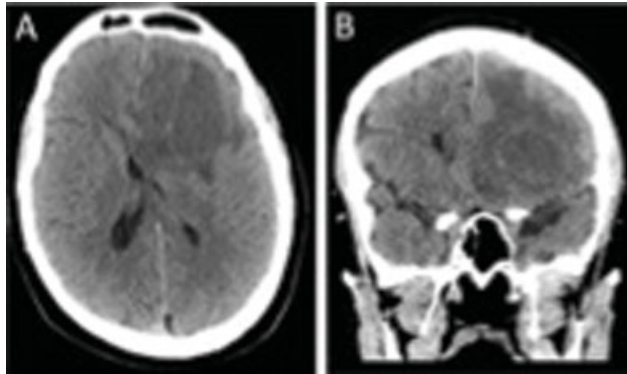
(A) Axial, (B) coronal CT demonstrating left frontal lobulated lesions.
